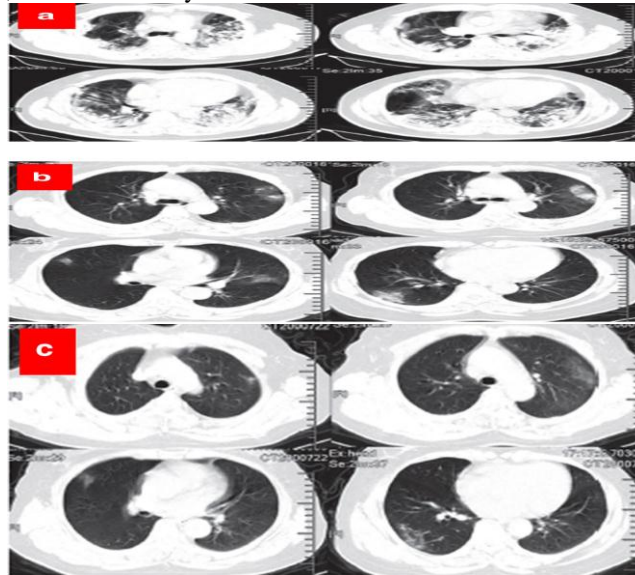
(a) shows typical appearance of bilateral multiple lobular and subsegmental areas in the chest CT images. (b) shows both bilateral ground-glass opacity and subsegmental areas in the chest CT images of non-ICU patients with COVID-19, and (c) shows only the bilateral ground-glass opacity in the chest CT images at later stage of the disease [20]
